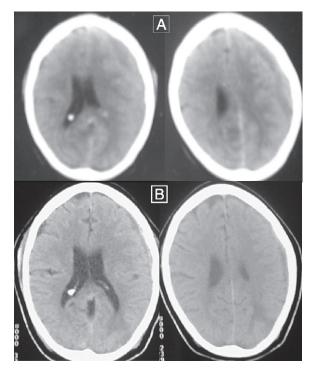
Non-operative treatment of CSDH. (A) Cranial CT scan at presentation showing the left frontoparietal chronic subdural with effacement of the body and the occipital horn of the ipsilateral lateral ventricle. There is also midline shift to the right. (B) Follow-up study 5 weeks later showing nearly complete resolution of the hematoma.
